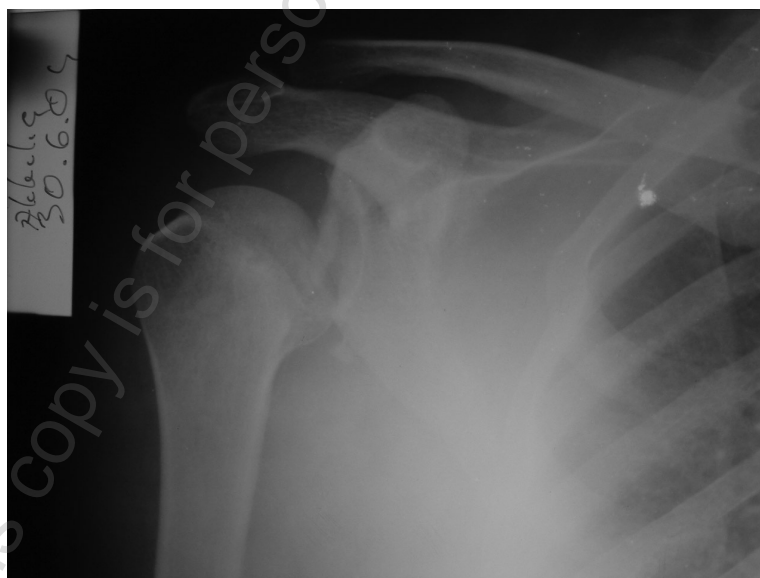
Preoperative antero-posterior shoulder X-ray
